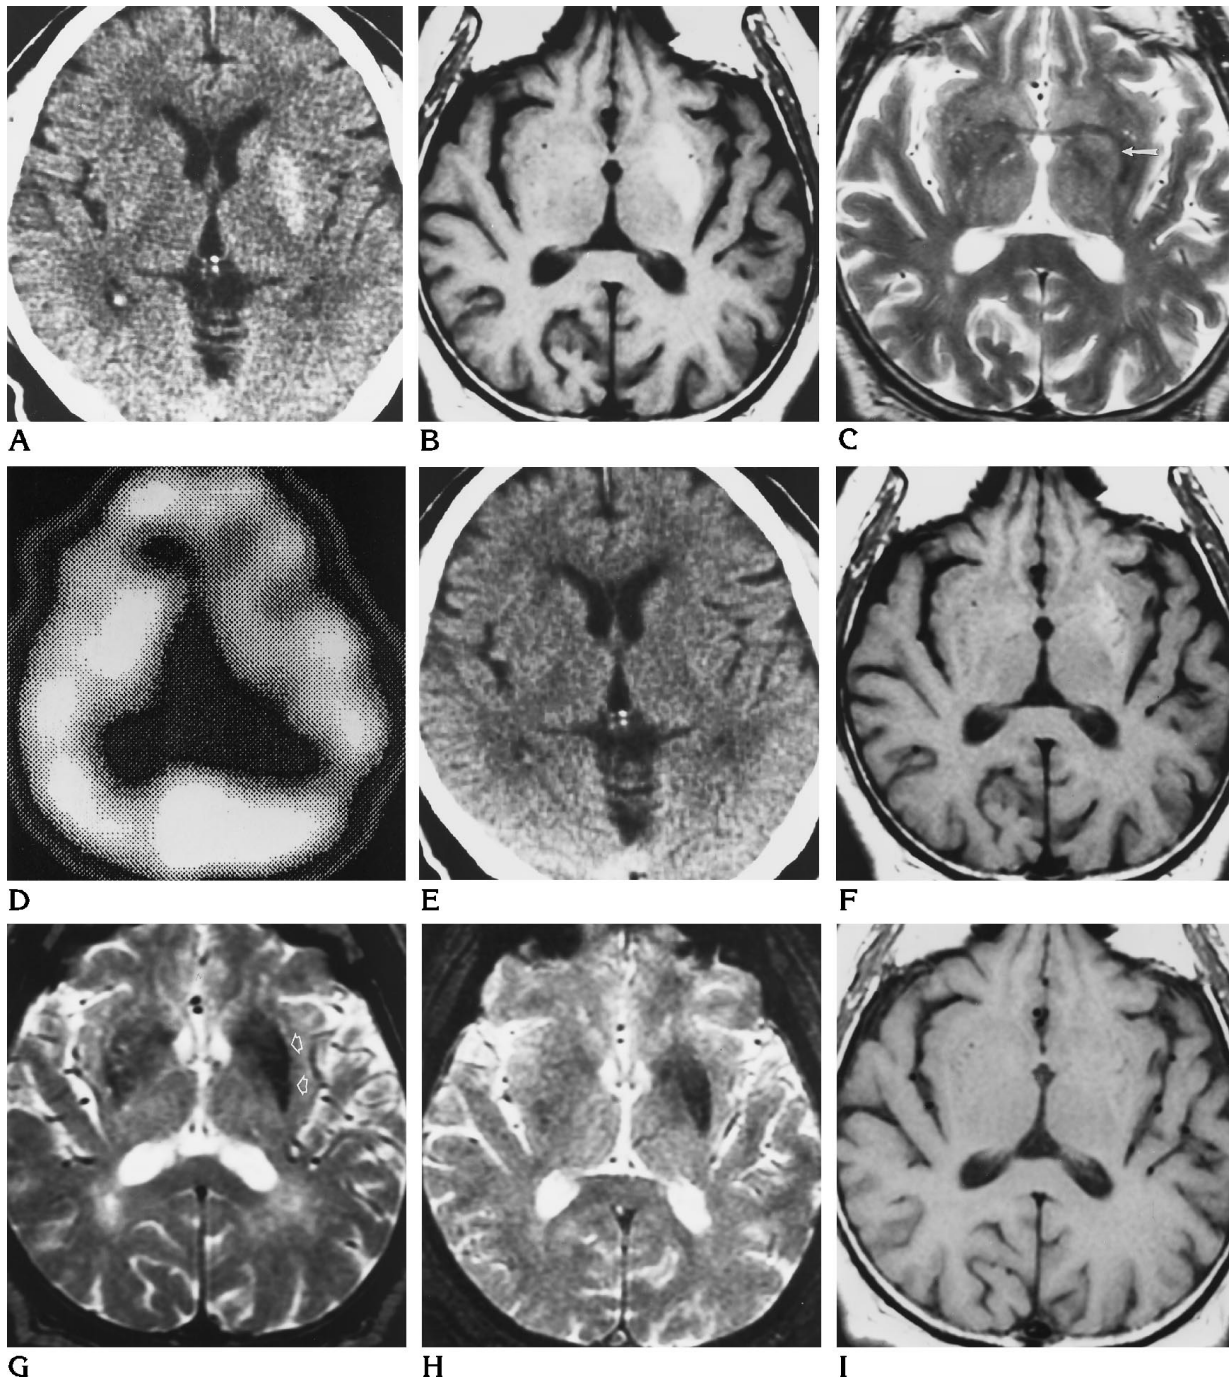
Case 1: 66-year old man with diabetes and abrupt onset of involuntary movements involving right limbs. CT scans were obtained 4 days after hemichorea; MR images at 6 days. (All CT scans were acquired with identical center and window level. All MR images were acquired with identical imaging parameters and were photographed with identical window and level settings.)
